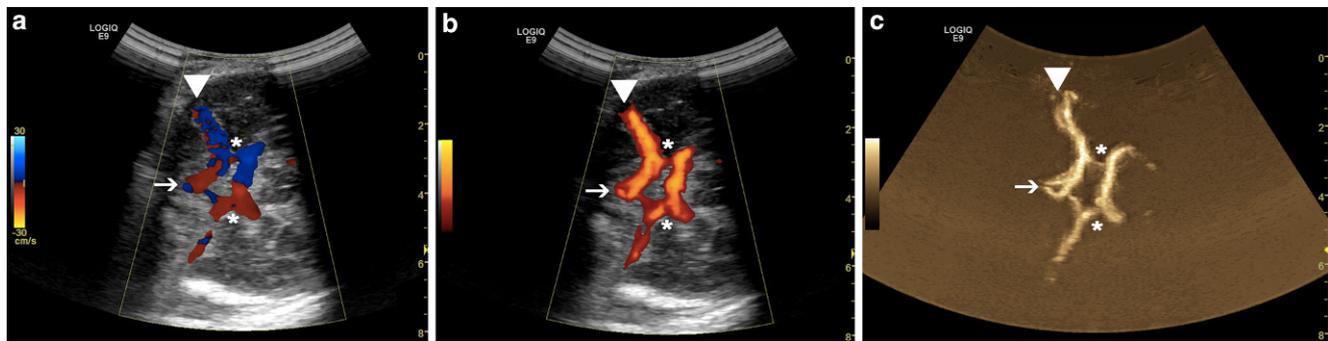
Color Doppler (a), power Doppler (b), and B-flow sonography (c) of the basal cerebral arteries in a 1-day-old female newborn (gestational age of 33 weeks). In this case differentiation of two vessels performs better with B-flow sonography: A2 segment of the anterior cerebral artery (arrow) and probe M2 segment of the middle cerebral artery (arrowhead). Asterisks (*) mark posterior communicating arteries
